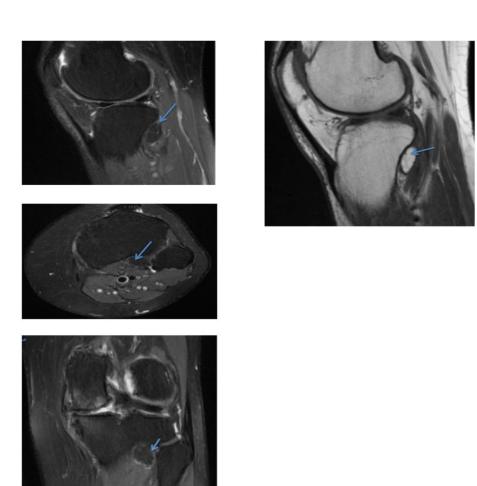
(A, B, C): Sagittal, axial and coronal DP Fat sat MR image, D: sagittal T1: demonstrating an ossific corticated body at the popliteus musculo- tendinous junction consistent with a cyamella (Arrow).
